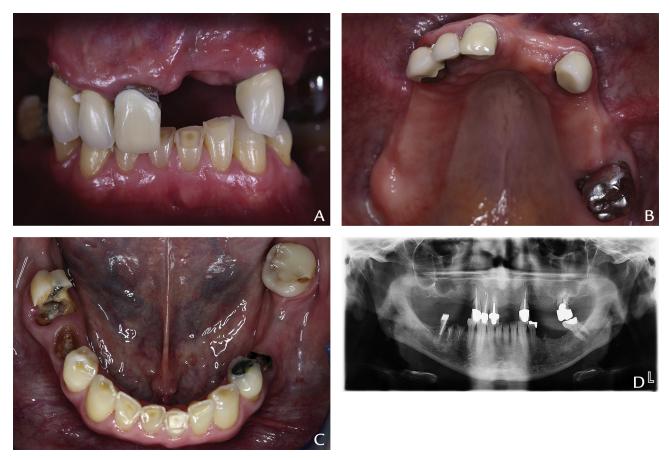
Before treatment. A, Frontal view. B, Maxillary occlusal view. C, Mandibular occlusal view. D, Panoramic radiograph.
